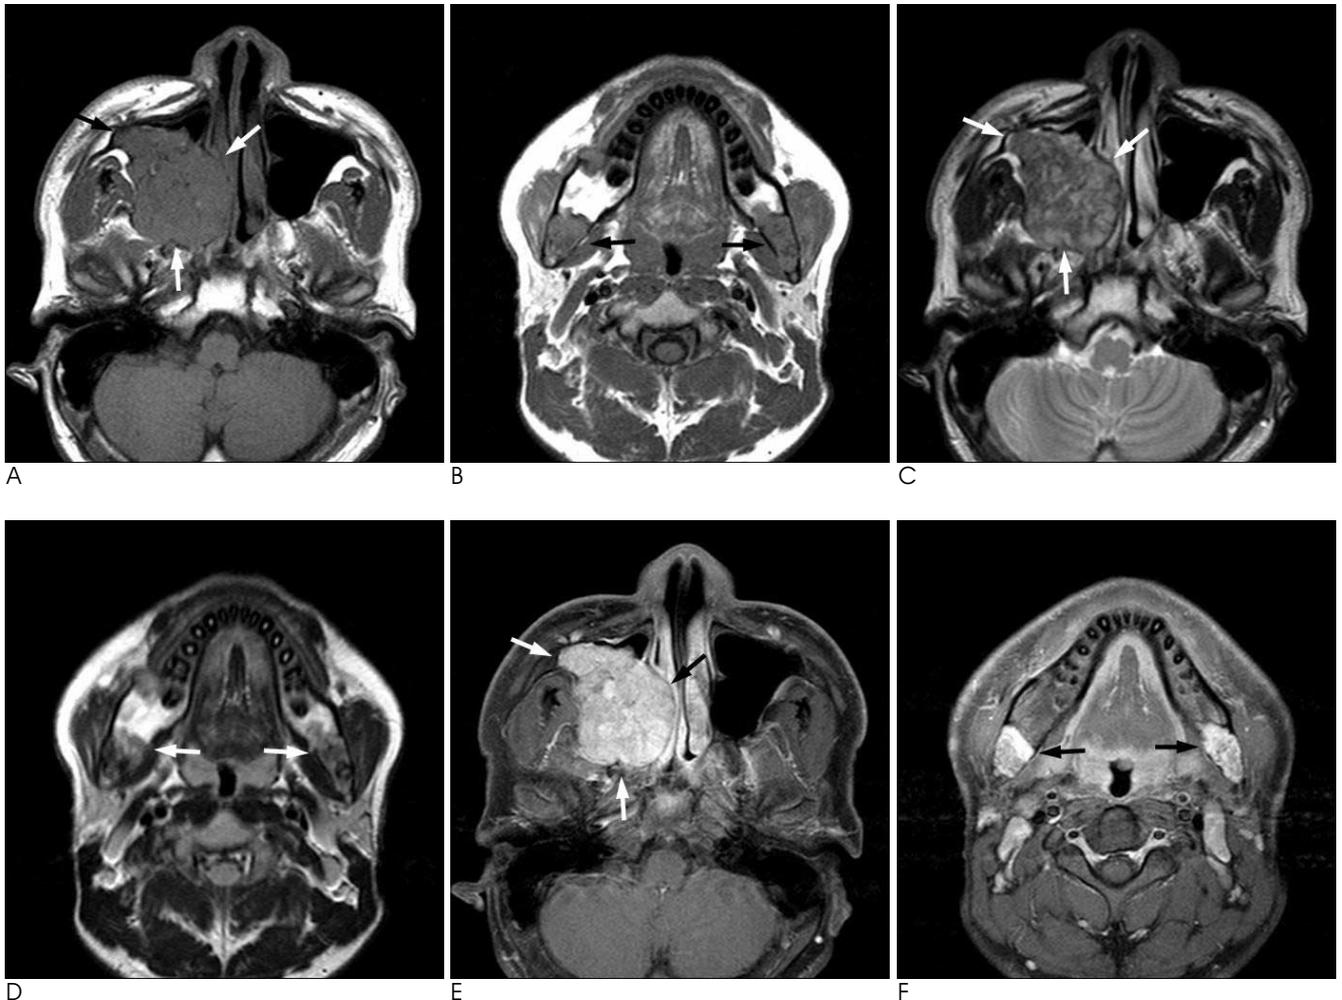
A-F. The multiple masses (arrows) in the right maxillary sinus and bilateral posterior mandible show low signal intensity on the T1-weighted images (A, B), heterogeneous low to intermediate signal intensity on the T2-weighted images (C, D) and intense enhancement of the masses (E, F) after the administration of contrast agent.
